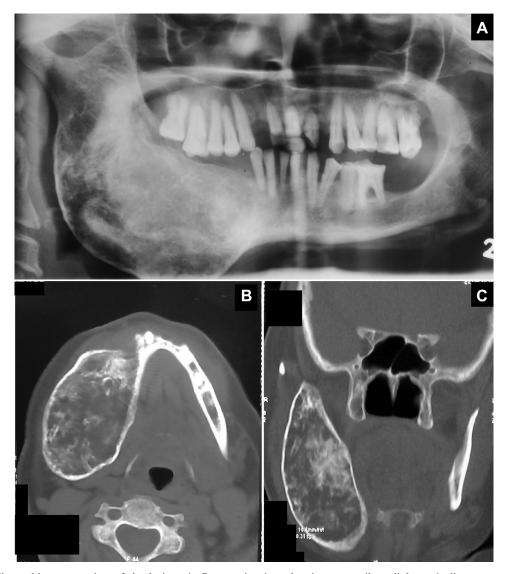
Radiographic presentation of the lesion. A, Panoramic view showing expansile radiolucent/radiopaque mass with ill-defined borders involving the right hemimandible. B, Axial computed tomography (CT) section showing significant buccolingual expansion with intact cortices. C, Coronal CT section showing superoinferior extent and diffuse central radiopacities within the body of the lesion.
